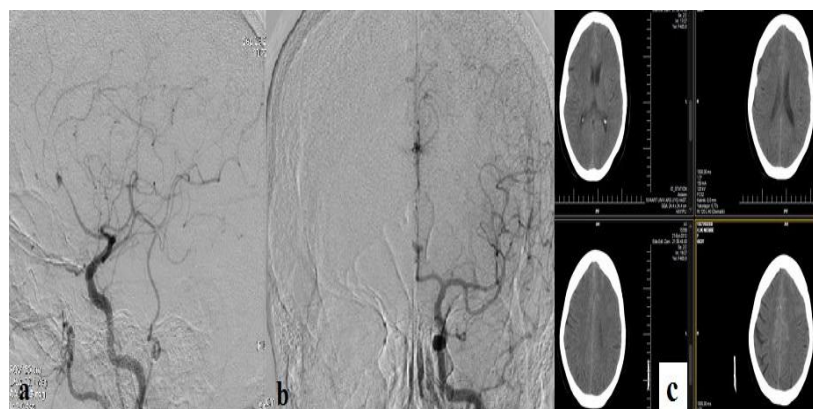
Preoperative lateral and A-P carotid angiogram showing a distal anterior cerebral artery aneurysm. CT scan showing interhemispheric subarachnoid hemorrhage (Case 2).
